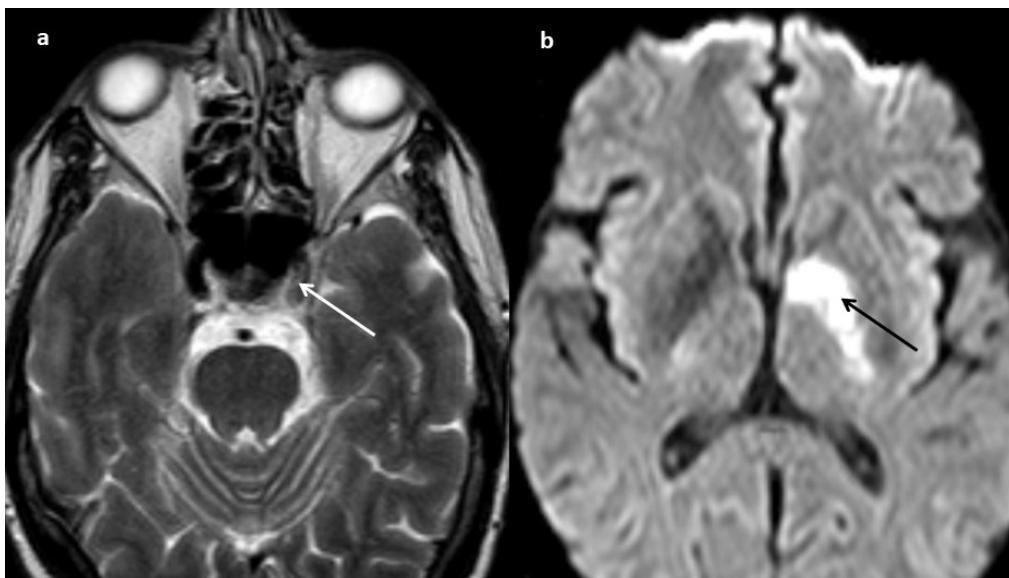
(a) Axial T2-weighted MRI show loss of flow void of the left internal carotid artery (white arrow). (b) DWI of the same patient shows an acute infarct in the left gangliocapsular region (black arrow).
